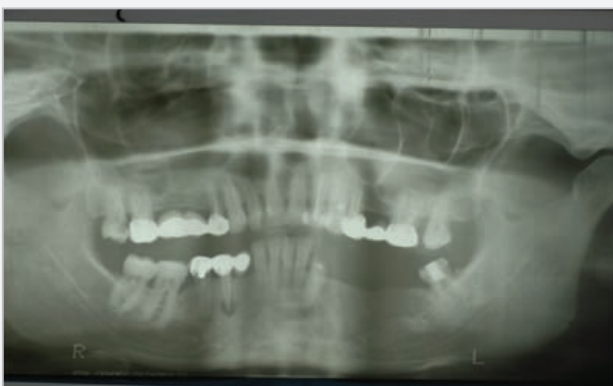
Preoperative x-ray. Narrow mandibular ridge.
